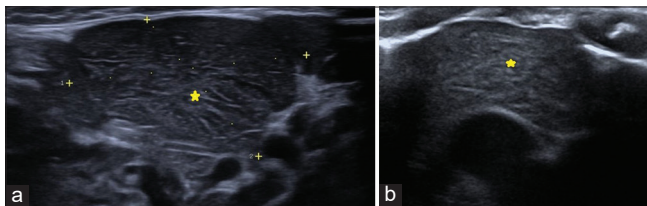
(a) High resolution ultrasound showing well defined hypoechoic lesion with multiple linear hyperechoic structures and foci in the left submandibular region, measuring 2.8 × 2.1 cm. (b) High resolution ultrasound image of the normal thymus gland in anterior mediastinum showing its unique echopattern with echogenic foci. Both the echopatterns were similar which is represented with a yellow *.
